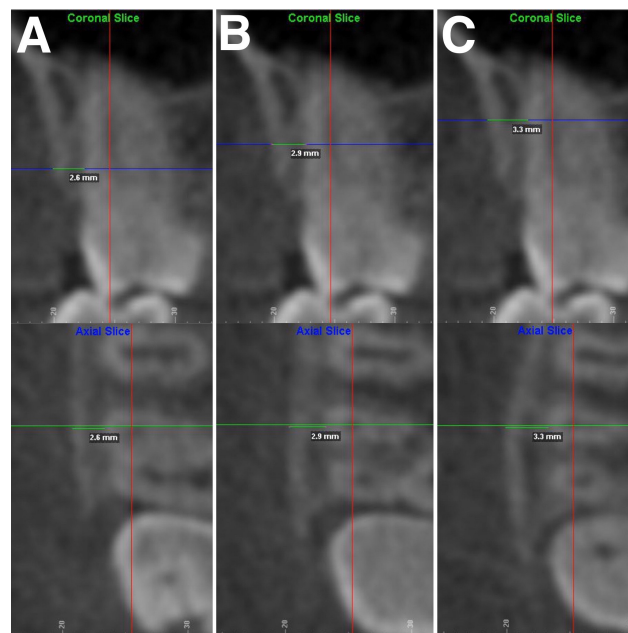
Measurement of buccal bone thickness on coronal (top) and axial (bottom) CBCT sections: A, B4; B, B6; C, B8.
